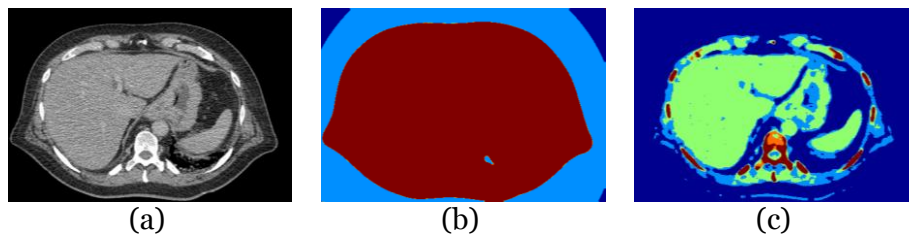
An example of five-class clustering on a 16-bits CT image (a) using TSMO method (b) and including a proposed range-constraint (c) [38].
